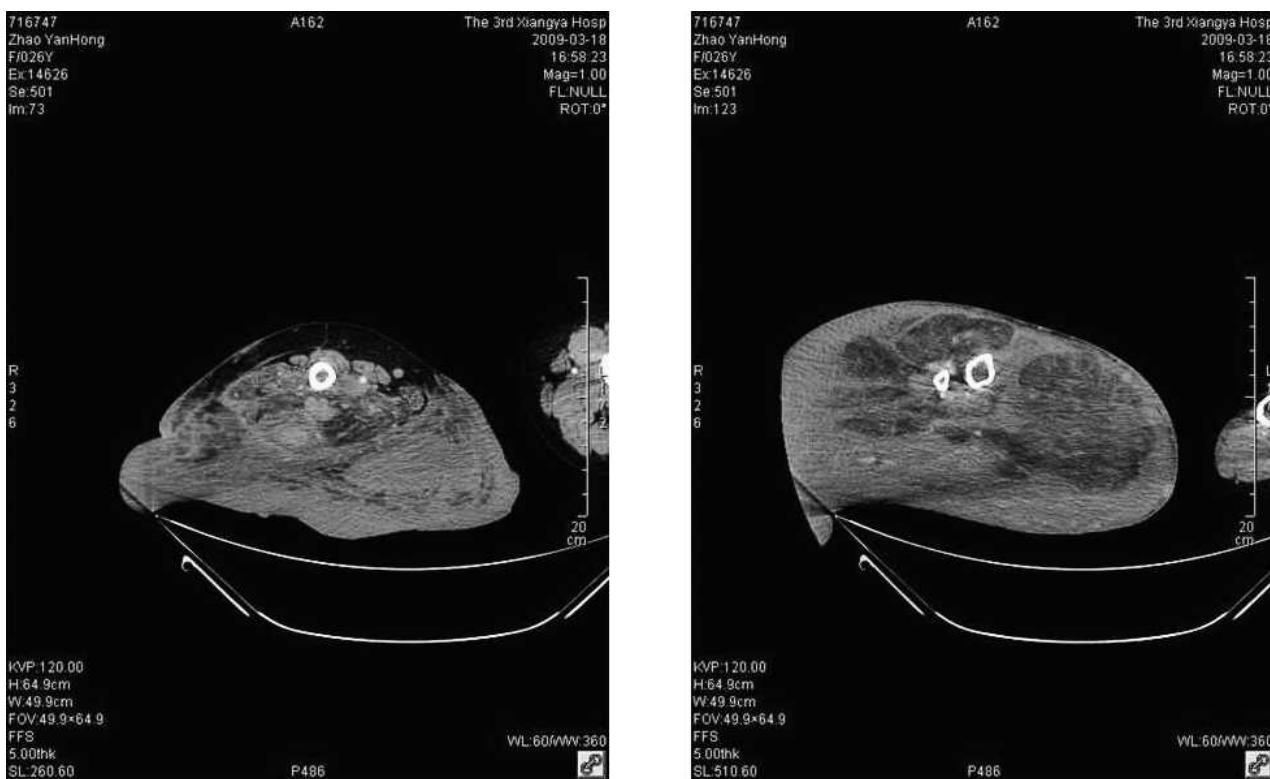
CT images before surgery.
